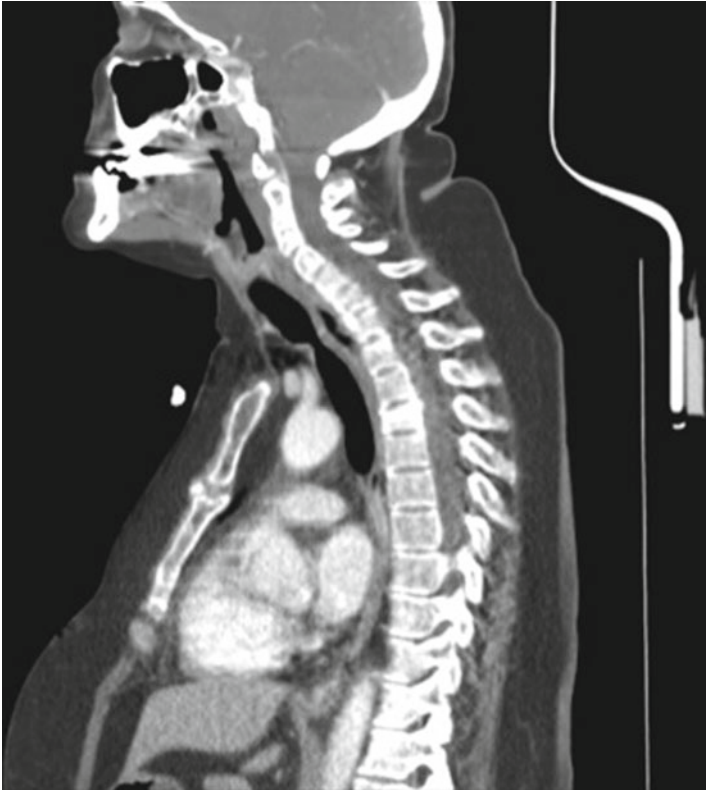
Sagittal CT view of the chest and neck revealing severe mid-tracheal stenosis (Reproduced with permission from Strohl and Packer [38])
